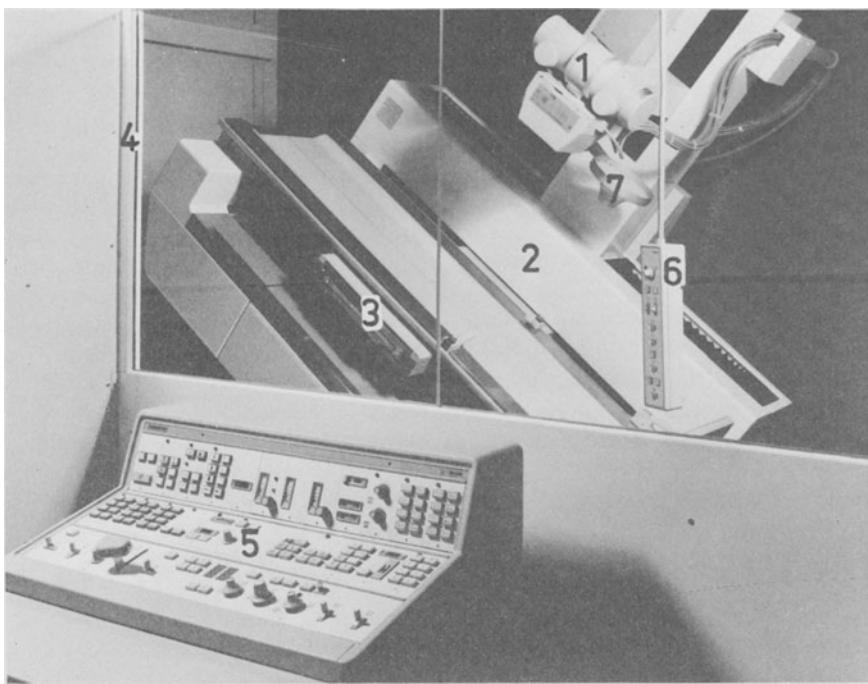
Remote-control stand. 1. X-ray tube with light-beam diaphragm (above couch tube); 2. table in angled position; 3. serial cassette changer, grid; 4. protective (lead-glass) partition; 5. control panel for remote control; 6. controls for use near the patient; 7. compressor folded out of the way.
